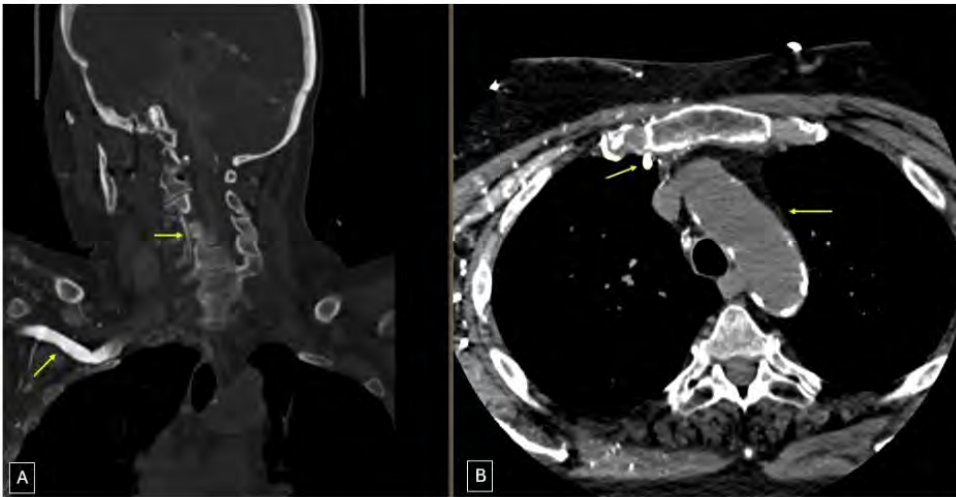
Coronal view (A) and axial view (B) of CT Angiogram demonstrating contrast opacification of right subclavian and its vertebral artery/anterior thoracic artery branches. Contrast doesn't reach arch of aorta and its other branches due to weak retrograde flow. This is indicative of a right sided intra-arterial contrast injection.
